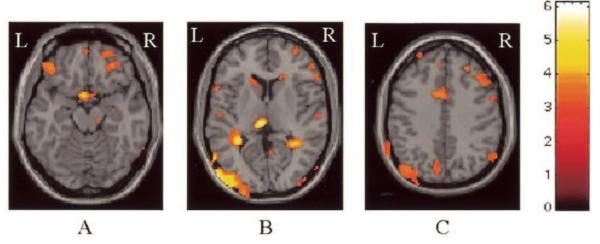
Color-coded areas (SPMt) of brain atrophy development in SPMS overlaid on a template T1-weighted image. Image A shows the involvement of the bilateral anterior orbital gyrus and left mammillary body. B shows the involvement of the caudate nuclei; left middle temporal gyrus; left thalamus; and frontal, parietal, temporal and occipital region. C shows the involvement of the cingulate sulcus and regions of frontal and parietal cortex.
